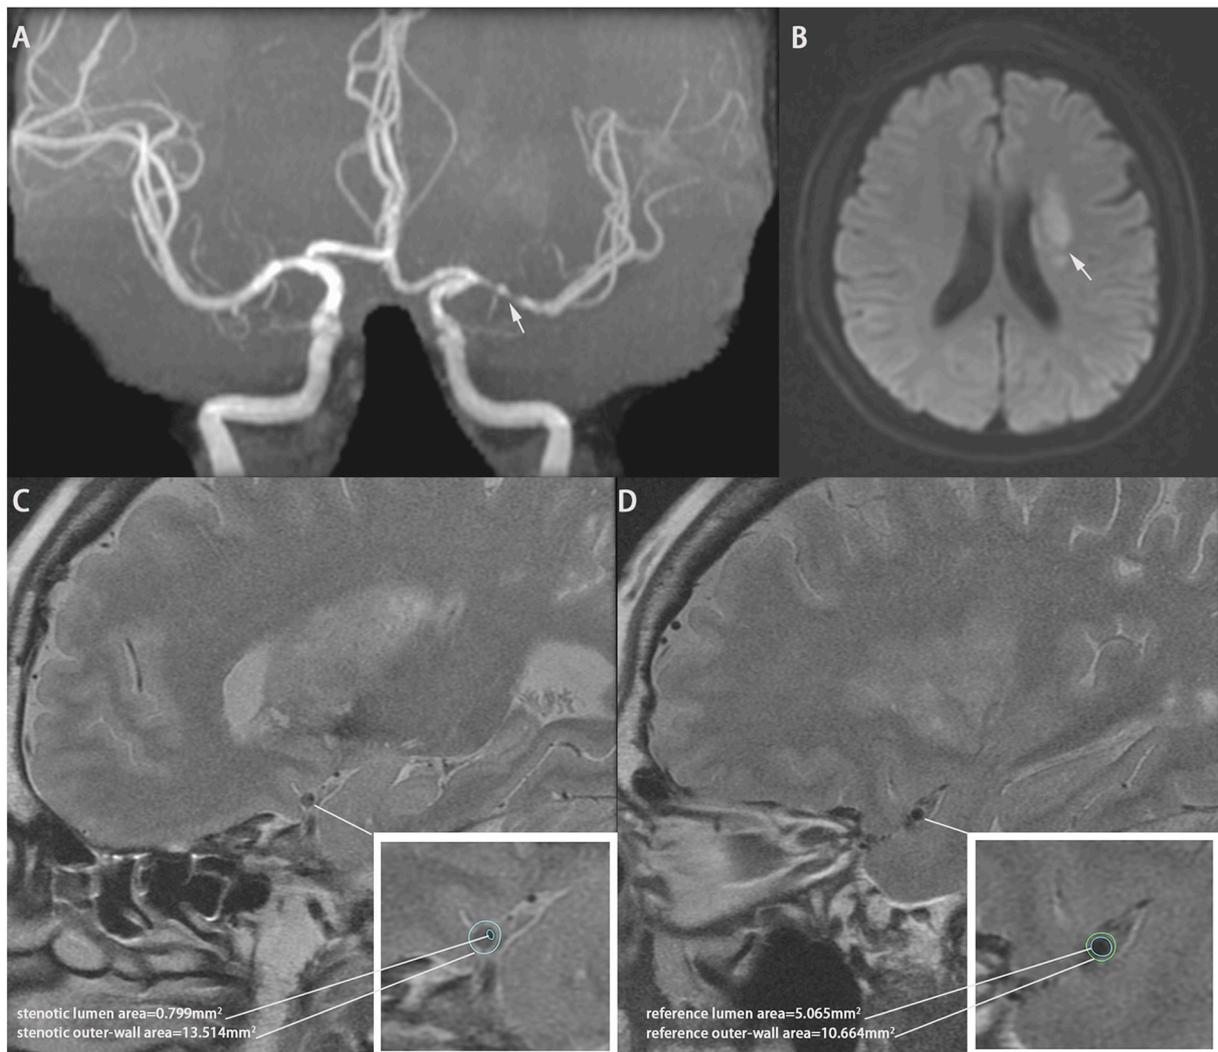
An example of the quantitative measurements of an eccentric symptomatic plaque. A 61 years old man with left MCA stenosis(A) had an acute cerebral infarction on diffusion weighted imaging(B). (C) and (D) show the quantitative measurements of the symptomatic eccentric plaque at the maximal stenotic site(C) and the reference site(D) on high-resolution T2-weighted imaging sequence, respectively. Plaque length = 5 slices. SPS = 4.388 (> 2.79) indicates a symptomatic plaque.
